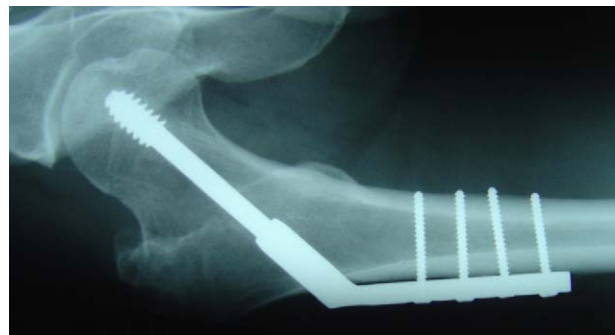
AP radiograph of the sliding hip screw.
